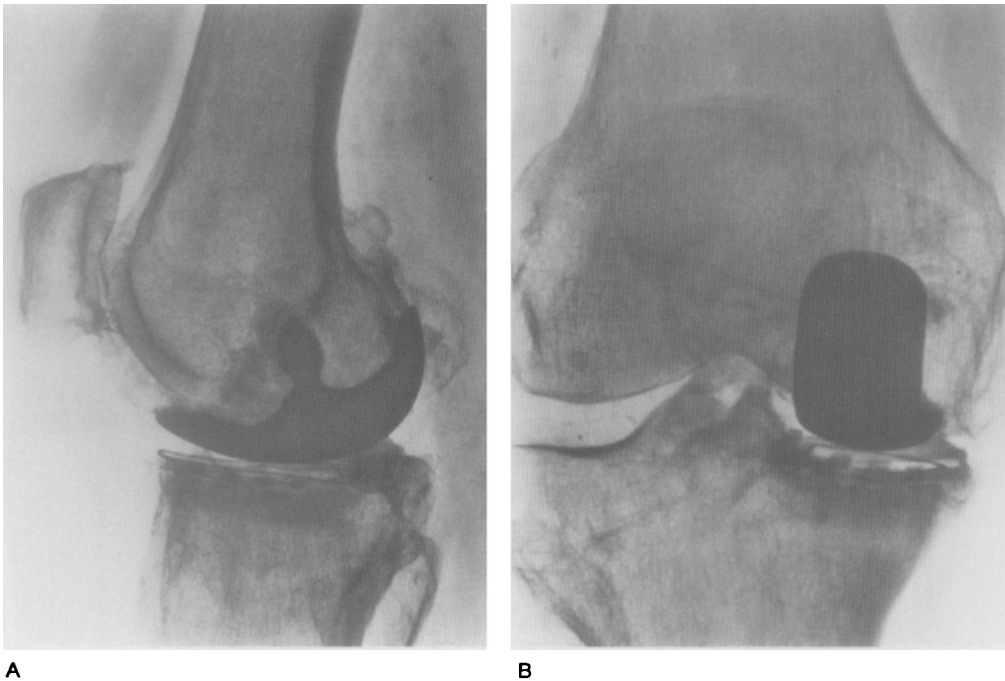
Case 006. 75-year old female with a Stage III medial primary arthrosis operated with a 6 mm tibial component. Roentgenograms four years after the arthroplasty.
